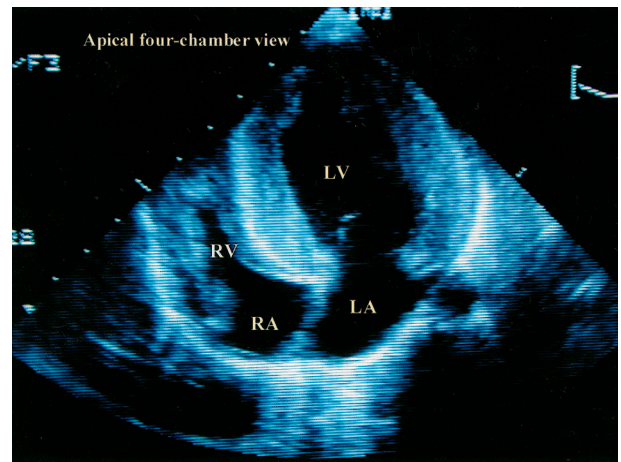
Echocardiogram demonstrates bi-ventricular and inter-ventricular hypertrophy.
